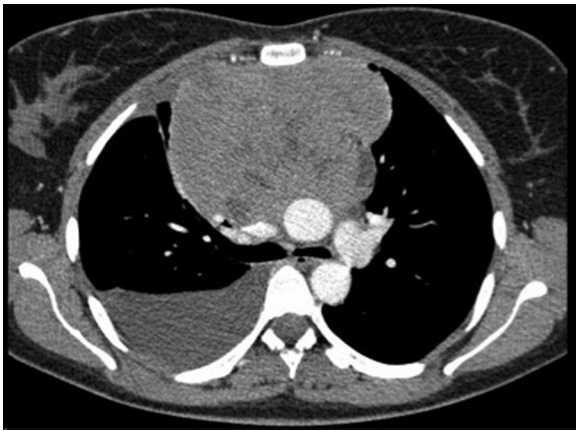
Postcontrast CT images at the level of crossing of left brachiocephalic vein and arch of aorta showing a large homogeneously enhancing mass lesion in anterior mediastinum (October, 2011).
